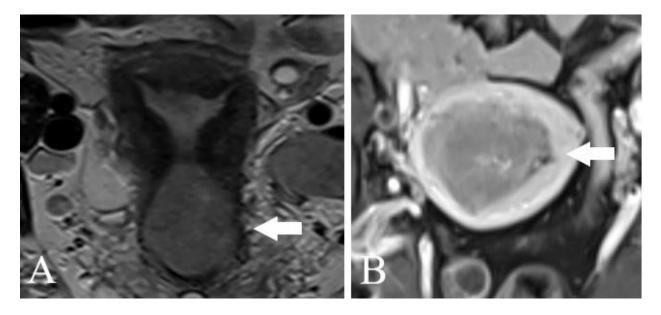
MR imaging. A. Cervical cancer, stromal invasion (T2 sequence) B. Endometrial cancer, myometrial invasion >50% (T1 sequence)
